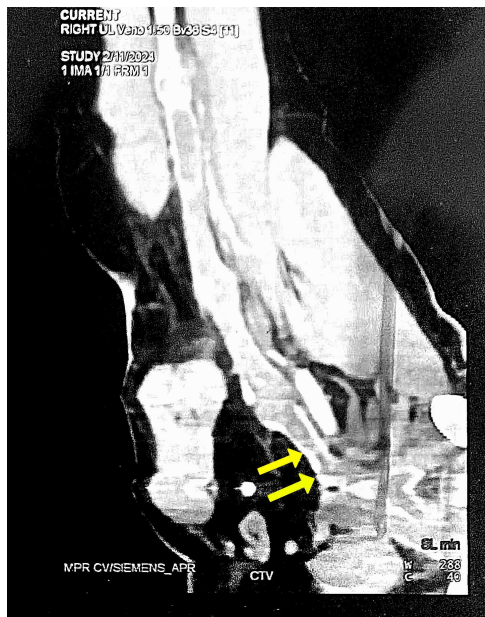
Computed Tomography (CT) venogram of right upper limb showing thrombus in subclavian and axillary vein.
